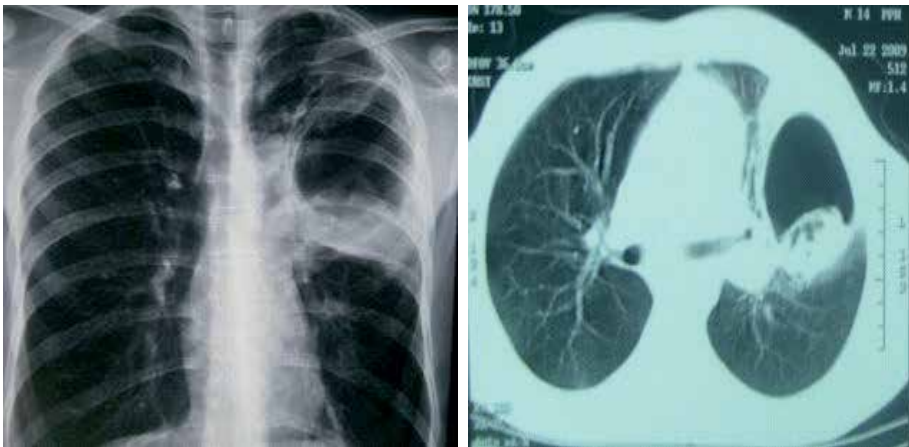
Chest X-ray showing a large cavity with a germinative layer in the left lung
